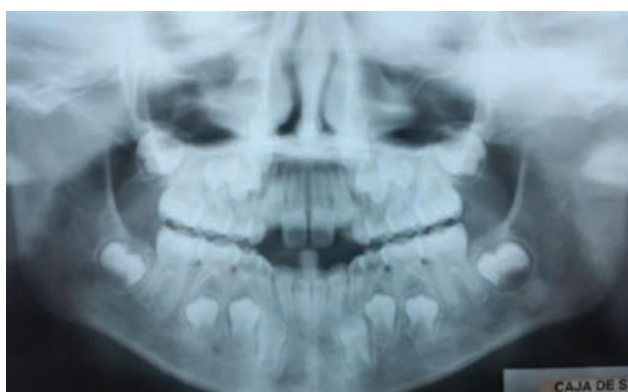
X-ray in which generalized crowding is observed.
